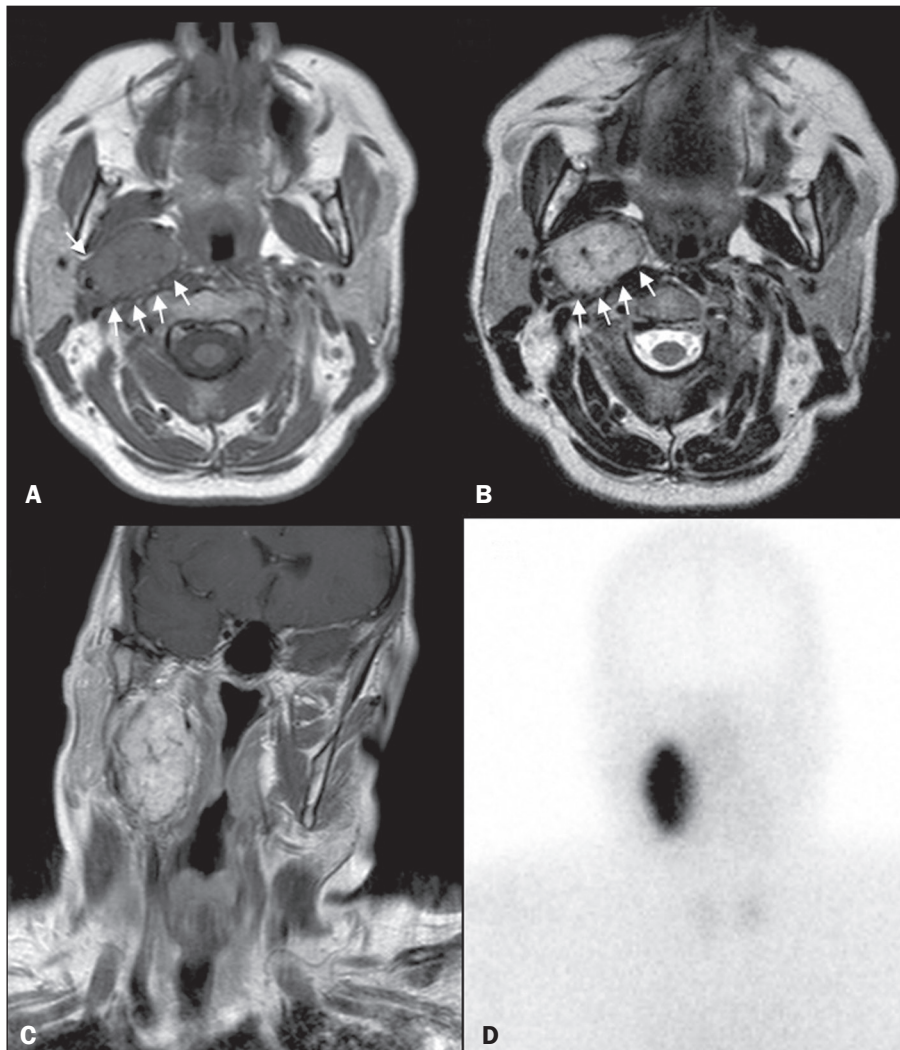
MRI and planar SRS images of patient A5, who received a confirmed diagnosis of paraganglioma. Axial T1W and T2W images (A and B, respectively) depicting a well-defined lesion (arrows), displacing the vascular bundle laterally and showing intense enhancement (C), in the right parapharyngeal space. Flow voids are part of the typical “salt and pepper” pattern. Planar SRS image (D) demonstrating strong ¹¹¹In-pentetreotide uptake.
